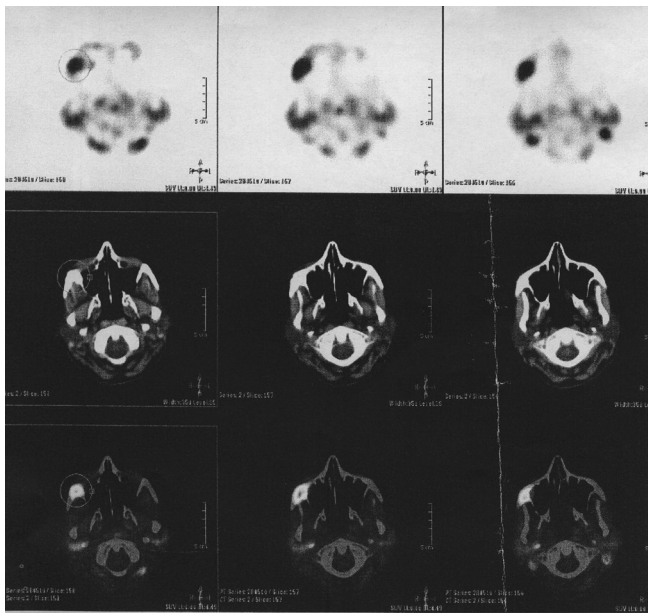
Axial CT-PET scan confirming the zygomatic metastasis.
